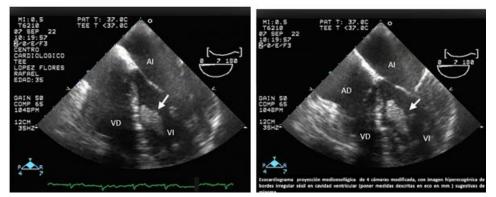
Transesophageal echocardiogram showing an adnexal mass in the left ventricle with pedicle located in the apex, compatible with myxoma.
